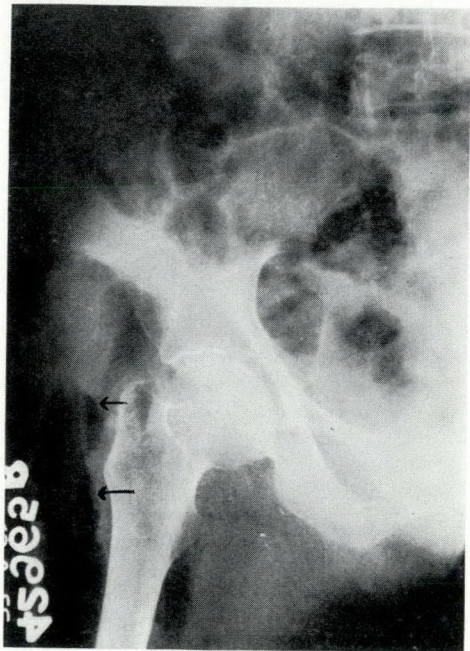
Radiograph of the pelvis and upper one-half of the right thigh showing soft-tissue cellulitis with gas.
